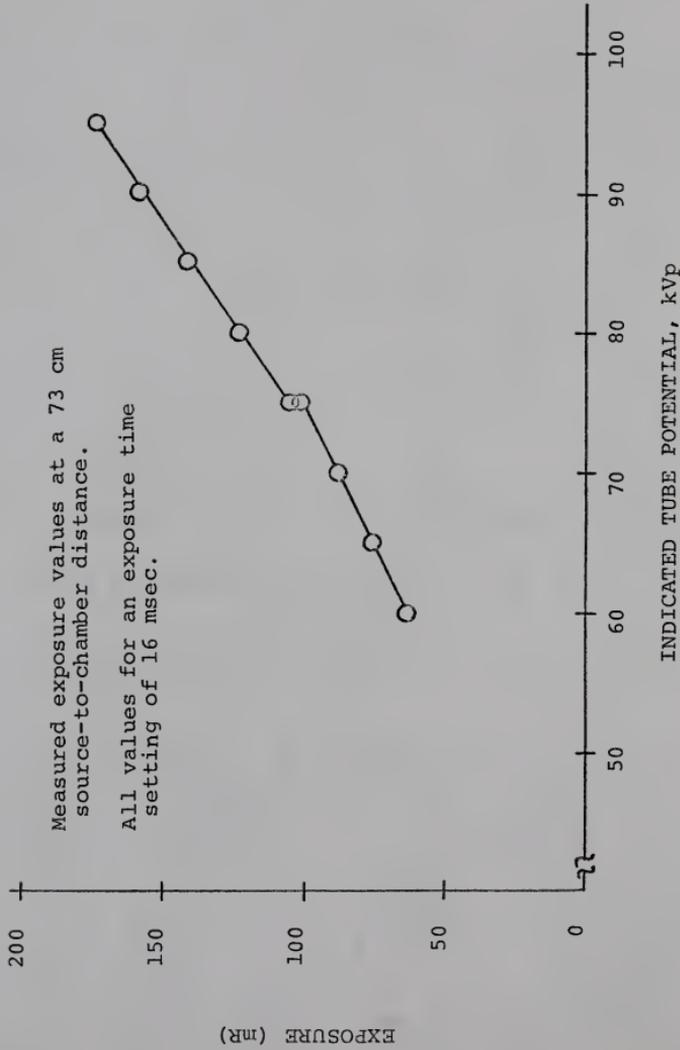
Measured Exposure as a Function of Tube Potential for Philips "Maximus-100" X-ray System Operating in Iso-watt Falling Load Mode.
